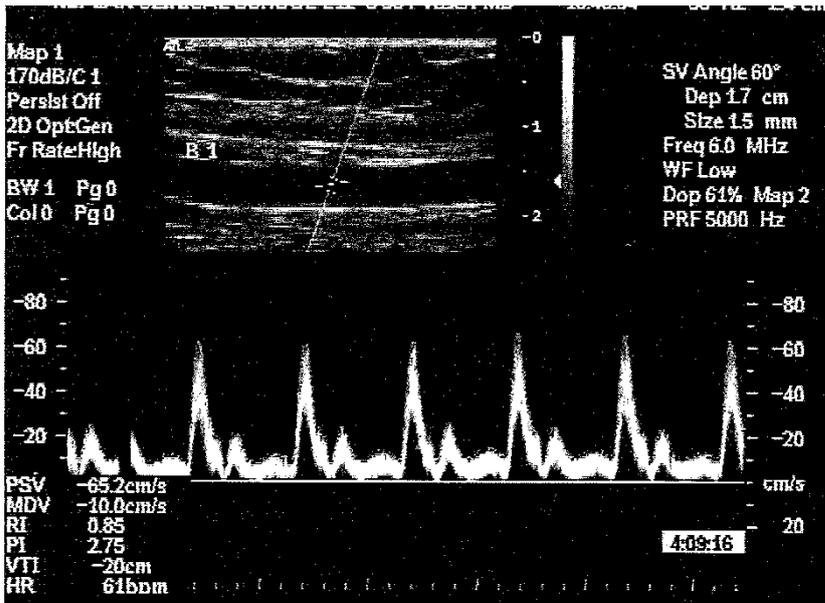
Typical Doppler waveform image demonstrating brachial artery basal VTI and heart rate. Sample gate placement can be seen in 2D part of image superiorly.
